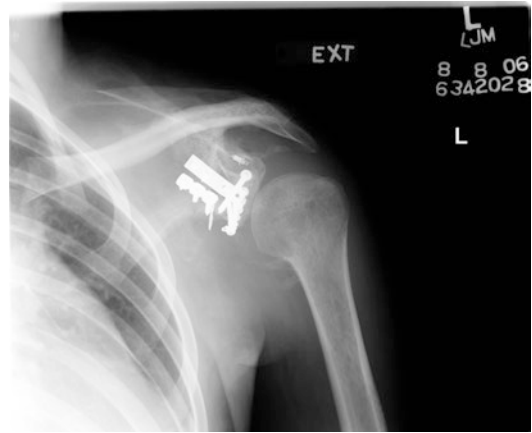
Scapula fracture. Left shoulder x-ray of a 19-year-old man who sustained a brachial plexopathy as well as a left scapula fracture for which he underwent surgical fixation
